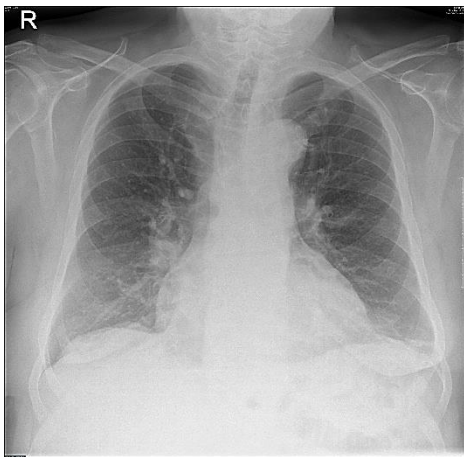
Chest X-ray on 2 months follow up.
